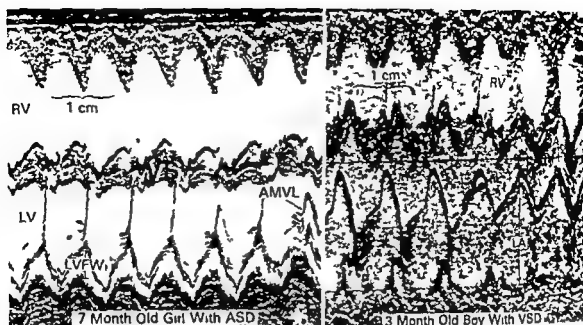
Echocardiograms from two patients. Left: A 7-month-old girl with a secundum type atrial septal defect (ASD). The right ventricle (RV) is dilated and the ventricular septum (VS) moves paradoxically during ventricular systole. The left ventricle (LV) is of normal size. LVFW = left ventricular free wall. AMVL = anterior mitral valve leaflet. Right: Echocardiogram from a 3-month-old boy with a ventricular septal defect (VSD). The left atrium (LA) is dilated and the aorta (Ao) is of normal size; consequently the LA to Ao ratio is increased.
